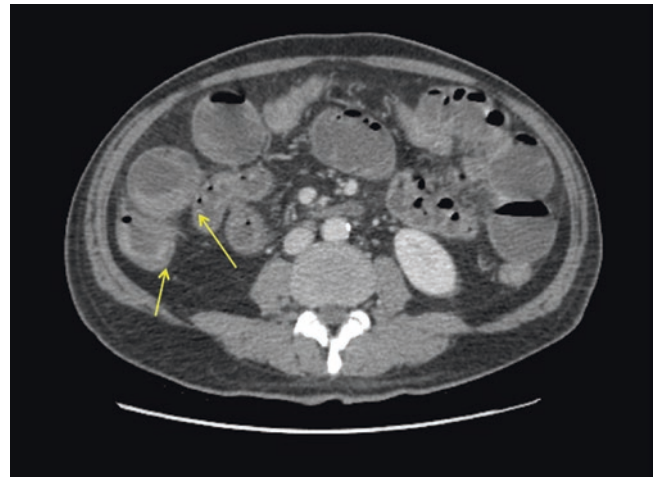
CT—small bowel dilatation with diffuse wall thickening and mucosal enhancement in setting of neutropenic enterocolitis
